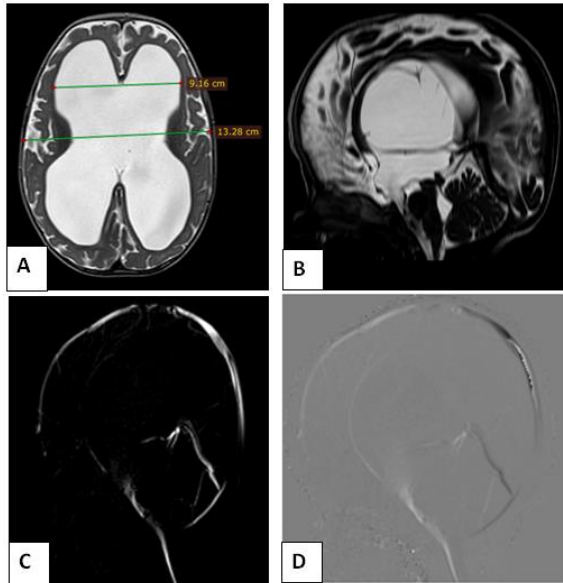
For follow-up, a 9-month-old female patient with a history of aqueductal stenosis had an ETV. Axial T2 WI at the lateral ventricle level on MRI (a) demonstrates hydrocephalus (Evan index = 0.69). b) Sagittal 3D DRIVE picture displaying an aqueduct obstruction. The sagittal magnitude
